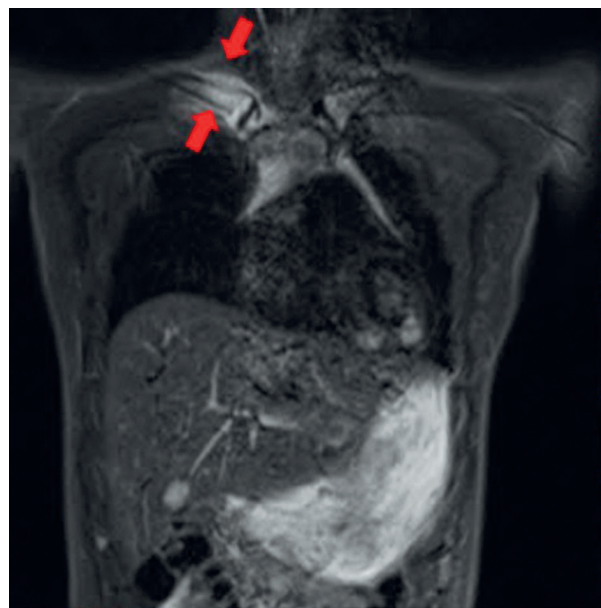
Magnetic resonance imaging scan demonstrating clavicular involvement in the inflammatory process associated with chronic recurrent multifocal osteomyelitis
